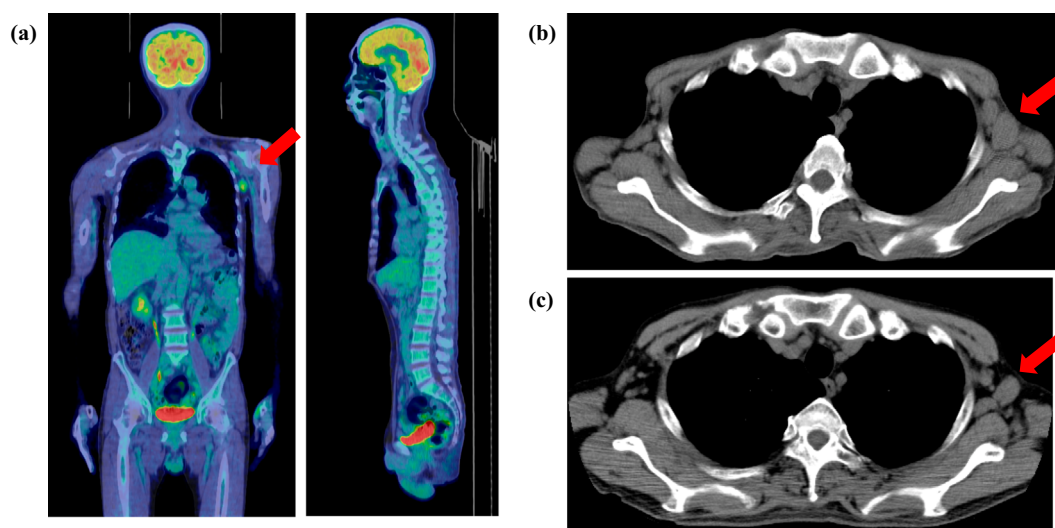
^{18}F -FDG PET-CT and plane CT obtained before and after the initiation of tirabrutinib. (a) PET-CT showing mild FDG accumulation in the left axilla (arrow) but no accumulation in CNS six months before tirabrutinib initiation. (b) Plane CT findings showing enlarged left axillary lymph nodes (arrow) on day -9. (c) Plane CT findings showing diminished left axillary lymphadenopathy (arrow) on day 158.
